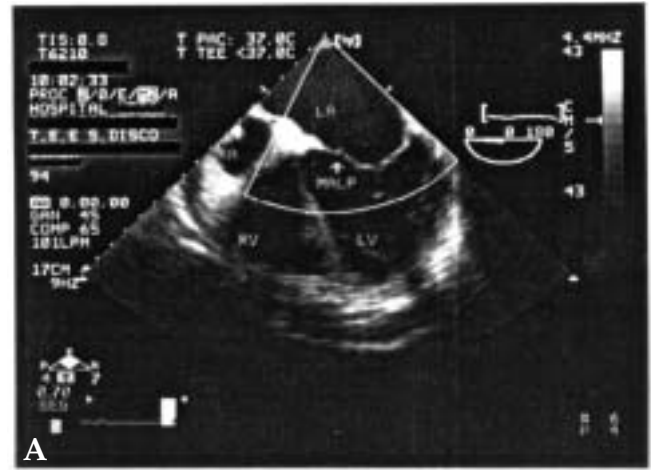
Transesophageal echo-Doppler image showing aortic destruction and Doppler color image showing aortic regurgitation.
